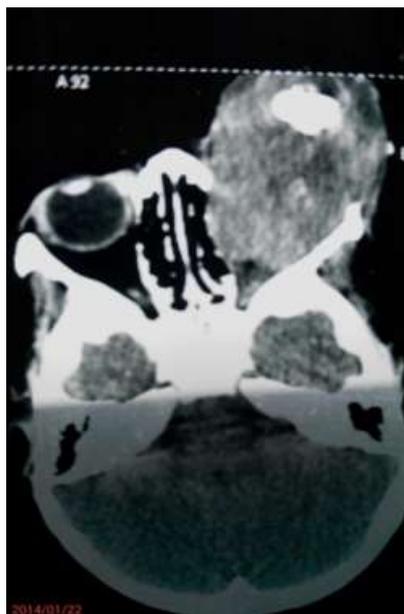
CT scan showing the calcifications in the left eye
